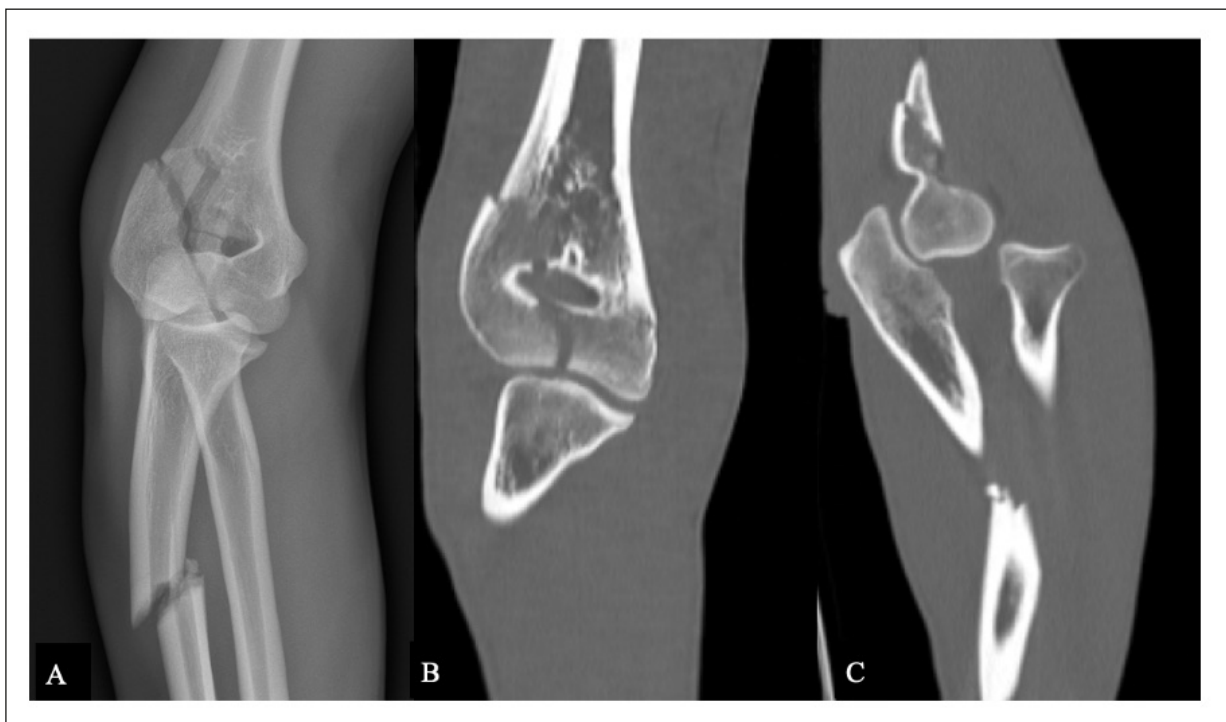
A, Anteroposterior x-ray of the elbow showing the fracture of the proximal third of the ulna and of the humeral blade associated with dislocation of the radial head; (B), CT coronal section showing humeral paddle fracture (AO 13-B1); (C), CT sagittal section showing the fracture of the ulna, the humerus and the anterior dislocation of the radial head.
